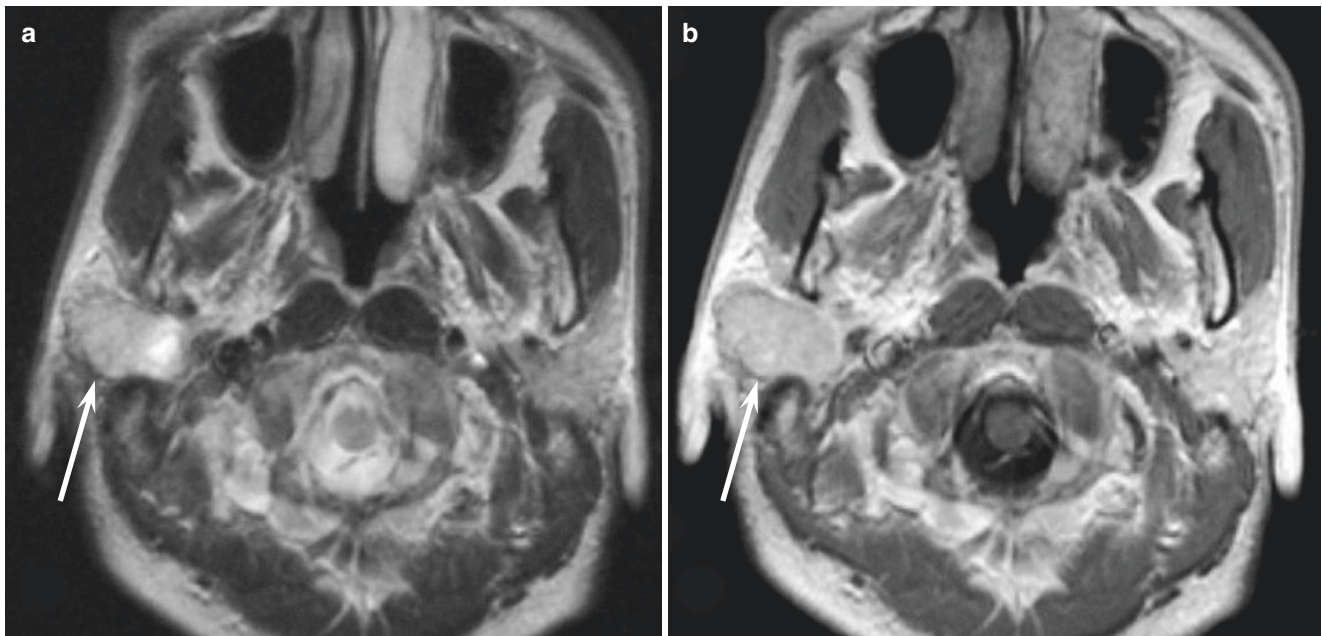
A 44-year-old man with secretory carcinoma of the right parotid gland. (a) T2-weighted image shows a well-demarcated, hyperintense lesion (arrow). (b) Gadolinium-enhanced T1-weighted image
